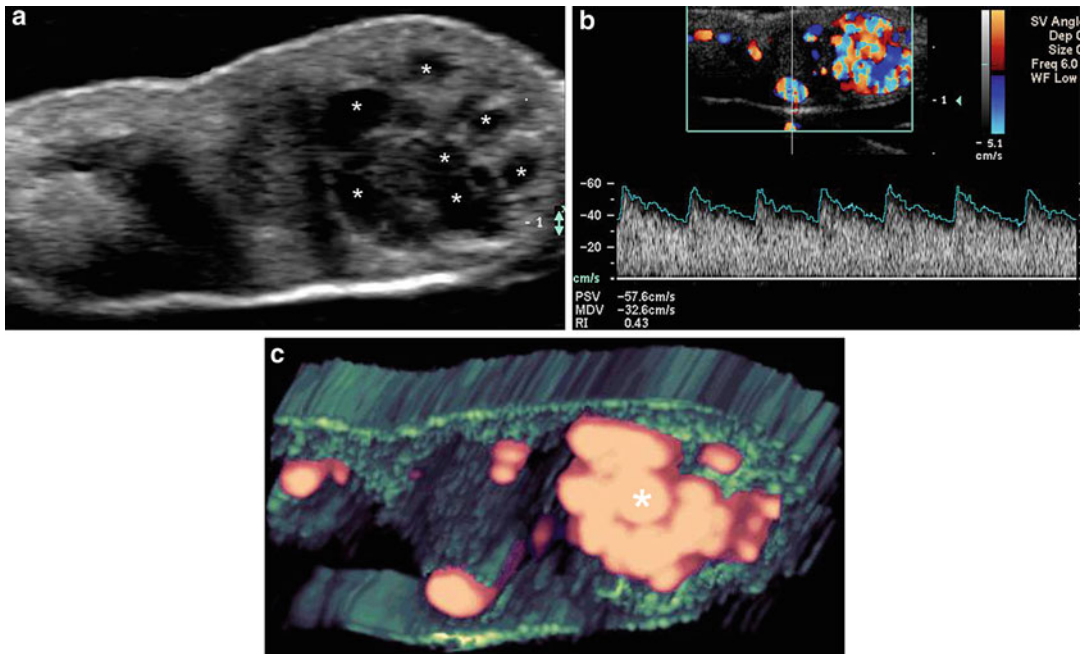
High-flow arterial vascular malformation (transverse views, lobe of the left ear pinna). (a) Grayscale ultrasound demonstrates several anechoic tubular ducts and pseudocystic structures (*) in the subcutaneous tissue.
